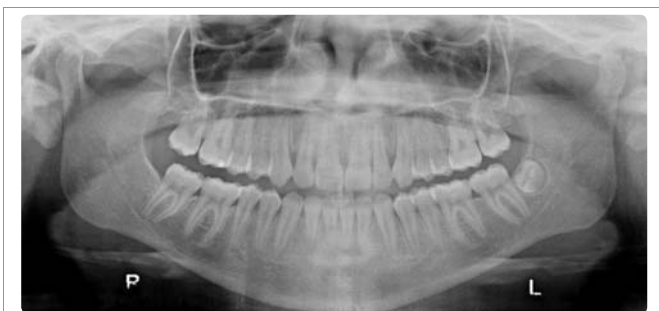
Panoramic radiograph taken during Treatment after 18months (final).
